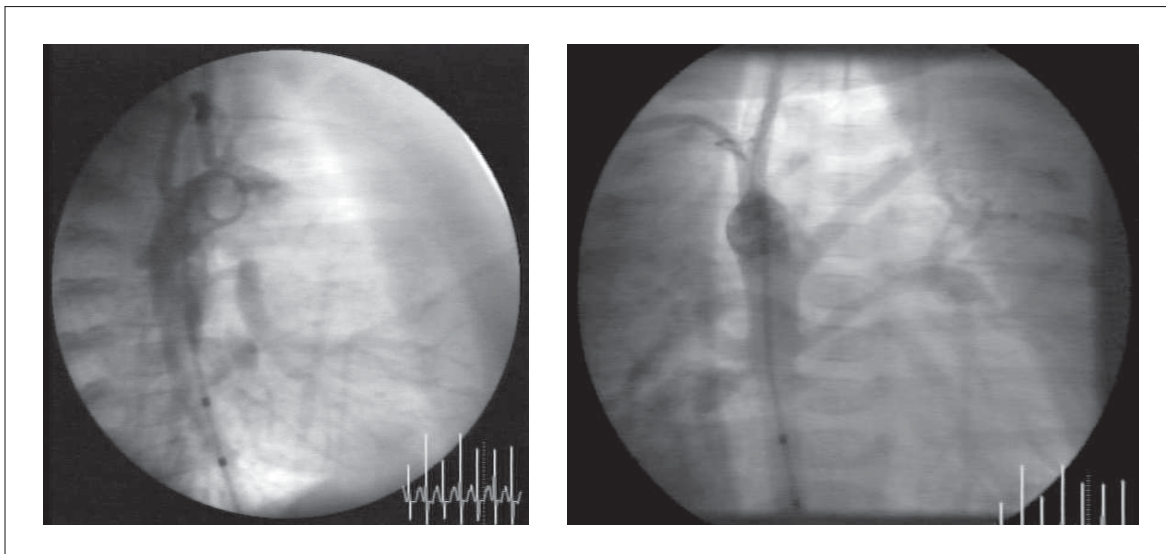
X-ray angiography of MAPCAs. Contrast agent injection in the aorta clearly demonstrate the passage of the blood through collateral arteries. Lateral (*left*) and frontal (*right*) views.
